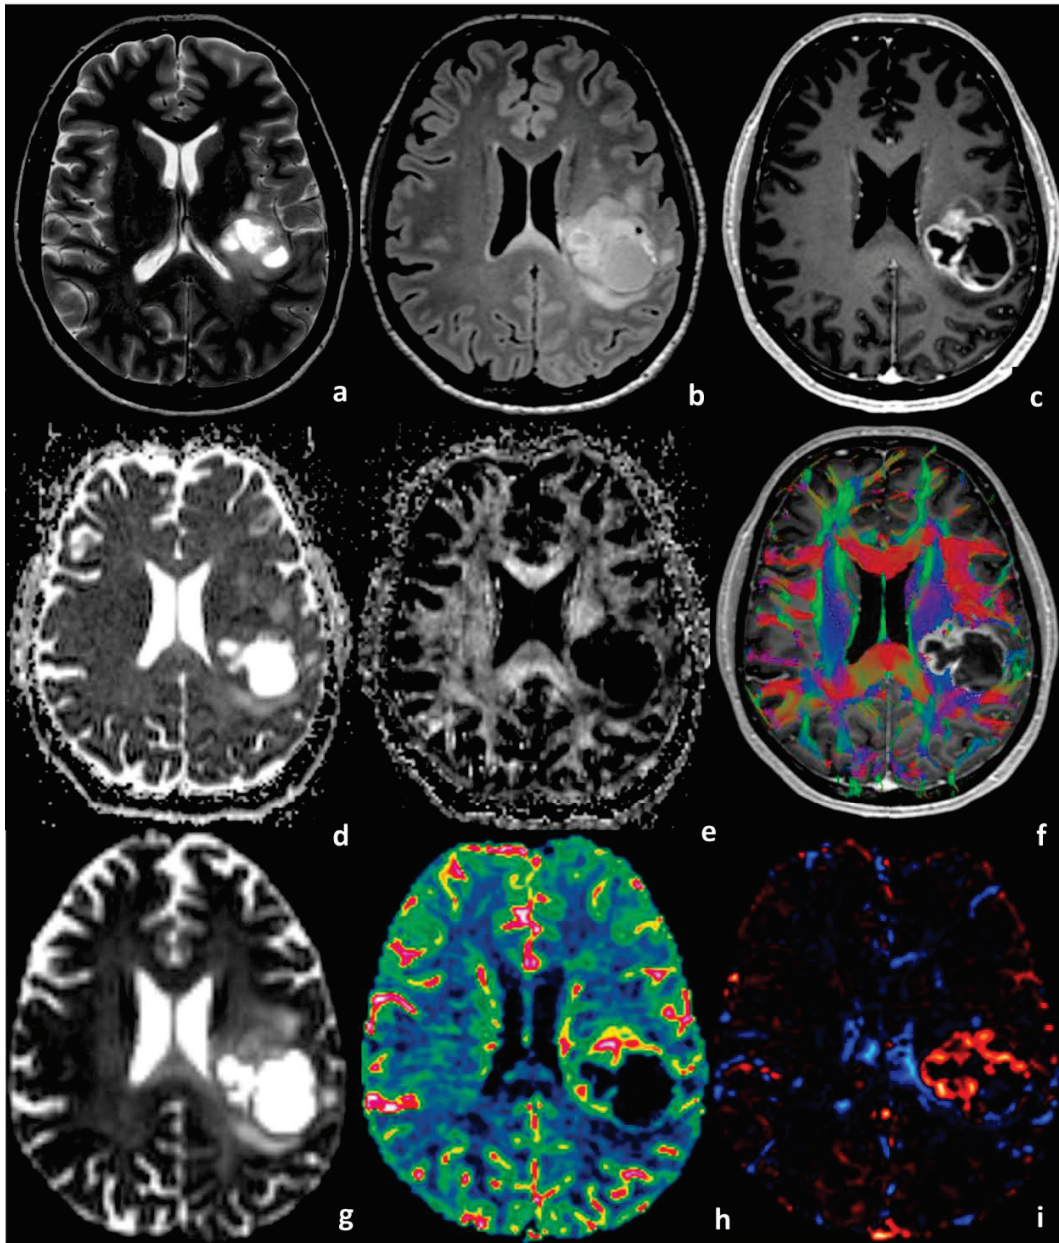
A 67-year-old man with a glioblastoma IDH wild type. a) Axial T2-weighted imaging shows an intraaxial heterogeneous tumor in the left frontal lobe. b) FLAIR image shows peritumoral hyperintensity, which suggests combination of tumor infiltration, edema and inflammation; c) contrast 3D MPRAGE shows irregular enhancement with central necrosis; d) ADC map, mean ADC in contrast-enhancing tumor core measured $0.87 \times 10^{-3} \text{mm}^2/\text{sec}$, indicating high tumoral cellularity, and in peri-enhancing zone $1.16 \times 10^{-3} \text{mm}^2/\text{sec}$, suggesting tumor infiltration; e-f) FA map with also directionally color-encoded map show FA abnormality in the tumor and in the peritumoral edema; g) RSI map; h) rCBV map clearly demonstrates areas of increased blood volume in contrast-enhancing tumor core; i) K2 map shows high capillary permeability in contrast-enhancing tumor core due to BBB damage.
